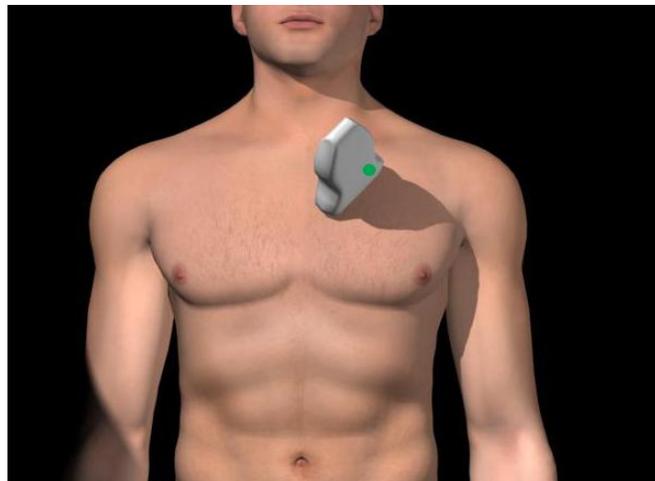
parasternal short axis views.*
